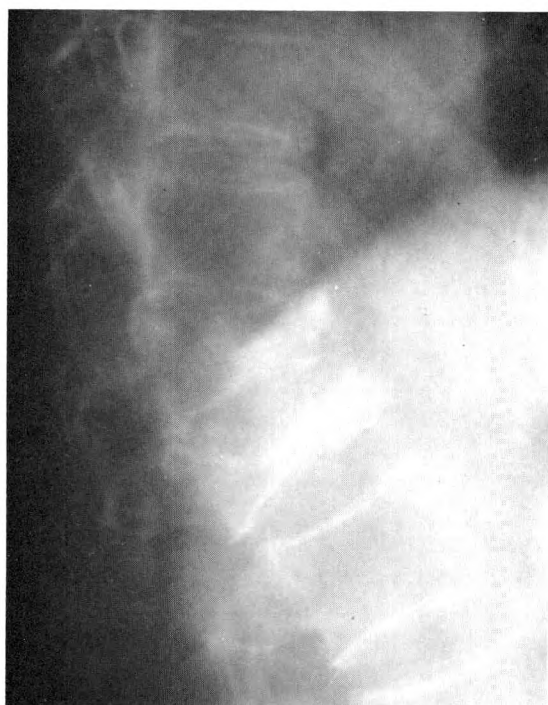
Case II. Close-up of lateral thoracolumbar spine roentgenogram showing marked collapse of T12 and L1 with gibbus formation. Irregular depression of superior end plate of T12 and smooth concavity of L1. Anterior projection of the collapsed vertebrae.
